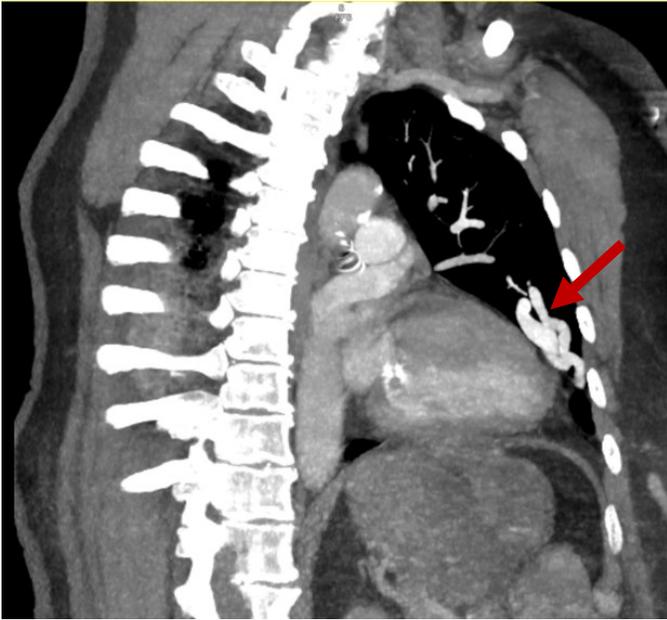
CT angiogram chest (right oblique MIP view) demonstrating 1.4 cm arteriovenous malformation with 6 mm feeding vessel in the lingula (arrow)
